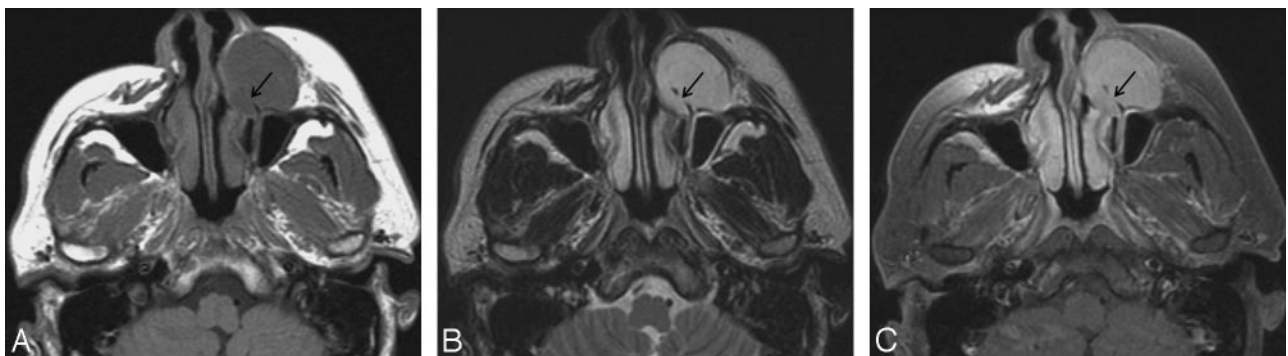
Case 1. Inflammatory type of MFH of the maxillary sinus in a 65-year-old woman. Axial MR images show a large ill-defined mass in the right maxillary sinus, which causes destruction of the sinus walls, extending into the anterior cheek and retromaxillary fat. *A* and *B*, Compared with the adjacent muscle, the signal intensity of the mass is mixed isointense and slightly hypointense on the T1-weighted image (*A*) and mixed hyperintense, isointense, and hypointense on the T2-weighted image (*B*). *C*, On the contrast-enhanced T1-weighted image, there is moderate heterogeneous enhancement at the periphery of the mass with the central areas remaining unenhanced. Also note that the mass invades the nasolacrimal duct, which is enlarged and filled with fluid (*arrow* in *B*).
